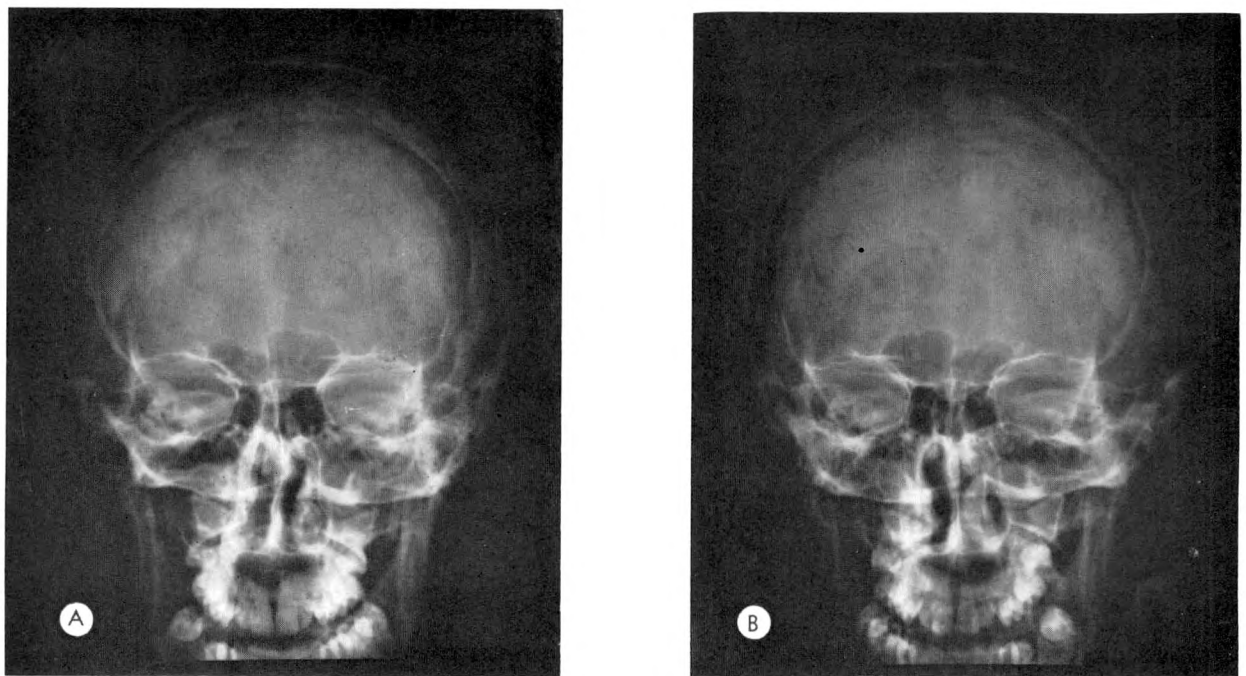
(A) Left eye. (B) Right eye. This is a posteroanterior projection—the orbits are the most distant structures. The sphenoid ridges and petrous can be seen as separate portions of the skull, although they are superimposed on the two dimensional roentgenogram.
